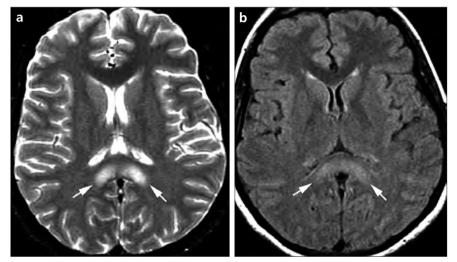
a*, *b*. Axial plane T2-weighted (a) and FSEIR (b) MR images show an area of increased signal intensity at the splenium of the corpus callosum (*arrows*).
